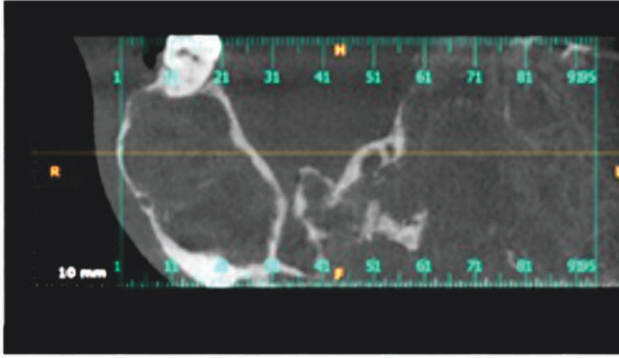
CBCT showing single hypodense lesion crossing the midline.
